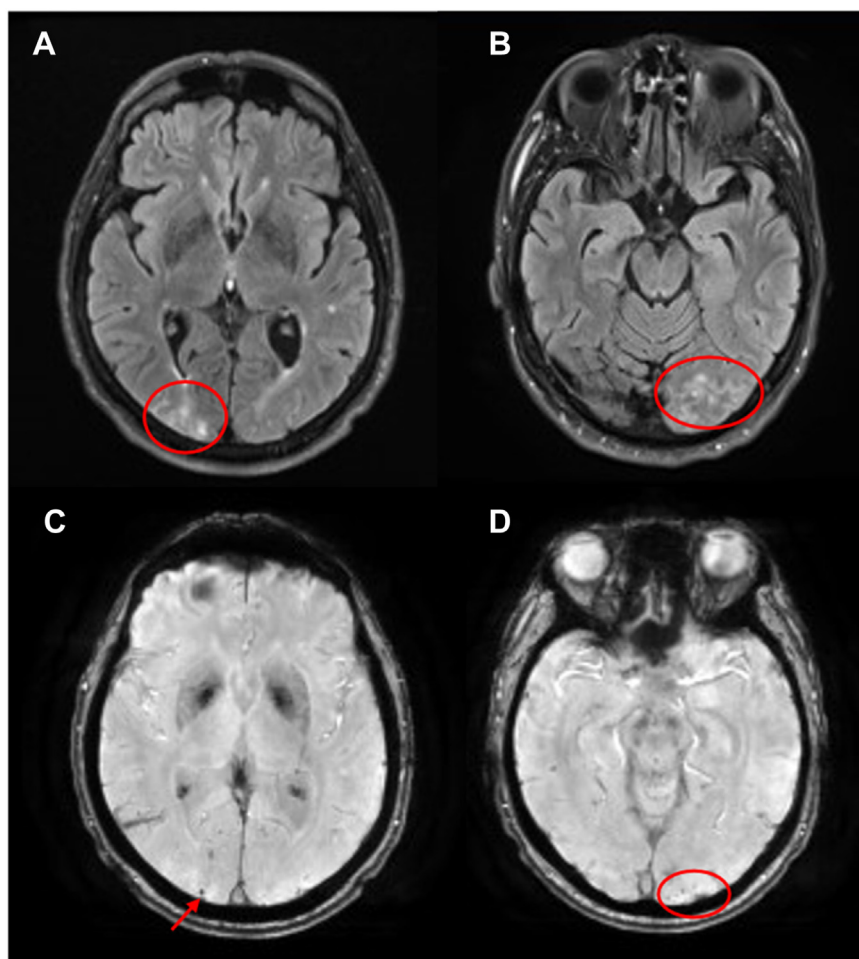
Example of cerebral amyloid angiopathy-RI edema and microhemorrhages, which has a similar radiographic appearance to amyloid-related imaging abnormalities. A, Right occipital parenchymal edema and sulcal effusion. B, Left occipital parenchymal edema and sulcal effusion. C, D Microhemorrhages in the regions of edema, single right occipital, and several clustered left occipital microhemorrhages. The authors acknowledge Dr. Petrice Cogswell and Dr. Jonathan Graff-Radford at Mayo Clinic-Rochester for providing these MRI images.
